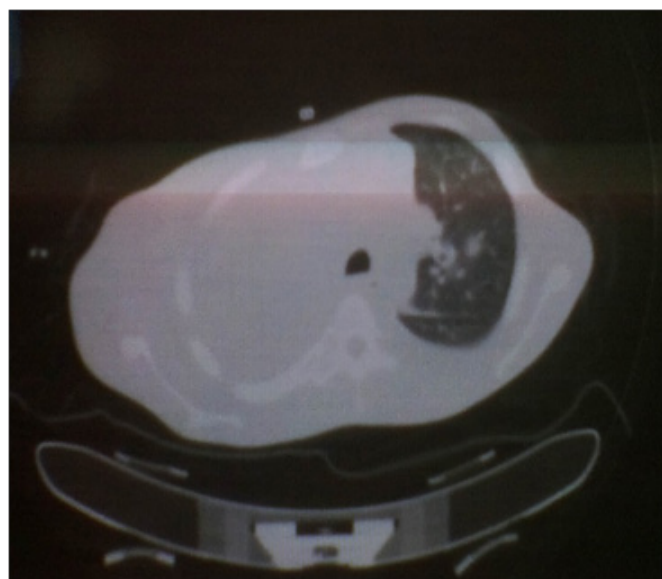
Simple CT Scan that show left mediastinal displacement.
